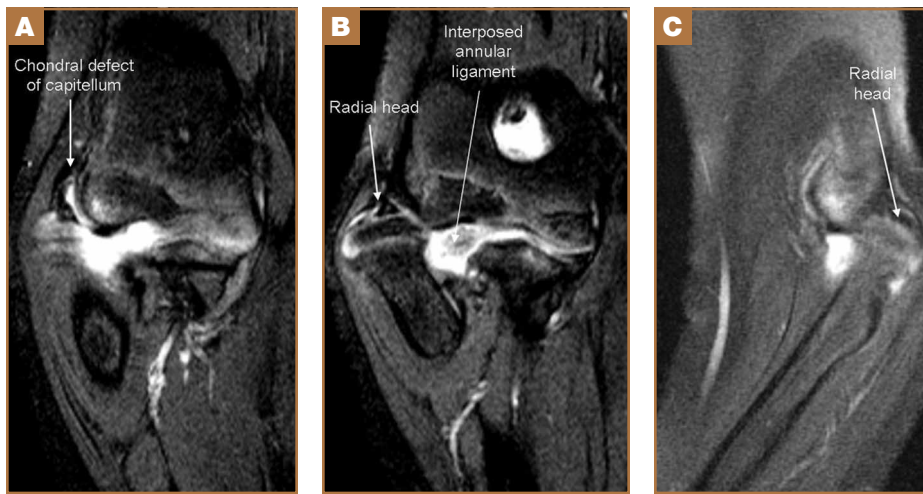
At initial presentation, (A,B) coronal and (C) sagittal magnetic resonance imaging of left elbow shows posterolateral radial head dislocation with interposition of annular ligament.
